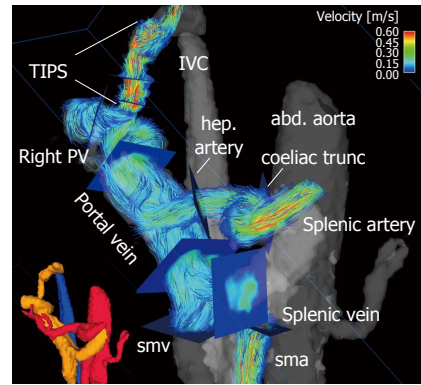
Four-dimensional flow magnetic resonance imaging in a 63-year-old female with liver cirrhosis after TIPS placement. Small lower left corner: three-dimensional (3D) segmentation of the liver and splanchnic hemodynamics (red: arterial system; orange: portal venous system; blue: venous system). Large figure: Color-coded 3D particle-traces visualization demonstrates increased velocities within the TIPS and the arteries. Blue analysis planes were positioned throughout the arterial and portal venous systems as well as TIPS to quantify liver hemodynamics. abd. aorta: Abdominal aorta; hep. artery: Hepatic artery; sma: Superior mesenteric artery; smv: Superior mesenteric vein; Right PV: Right portal vein branch; IVC: Inferior vena cava.
